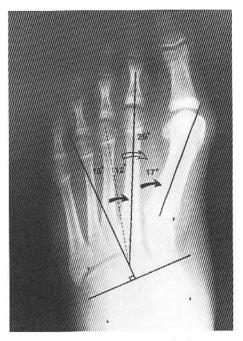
X-ray of a foot with a high metatarsus adductus.
